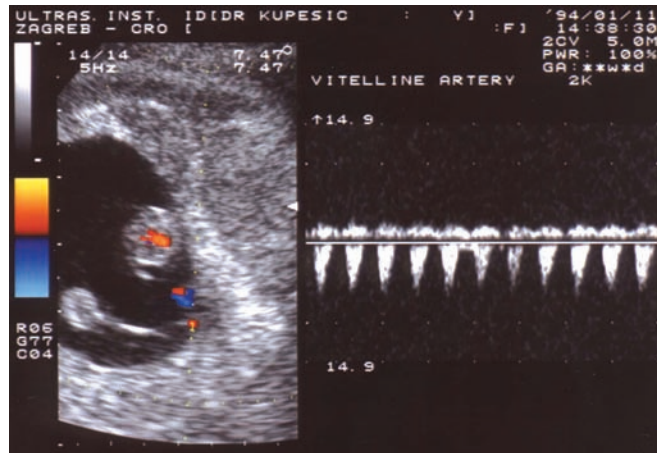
Color Doppler signals are easily obtainable from the vitelline stalk.
